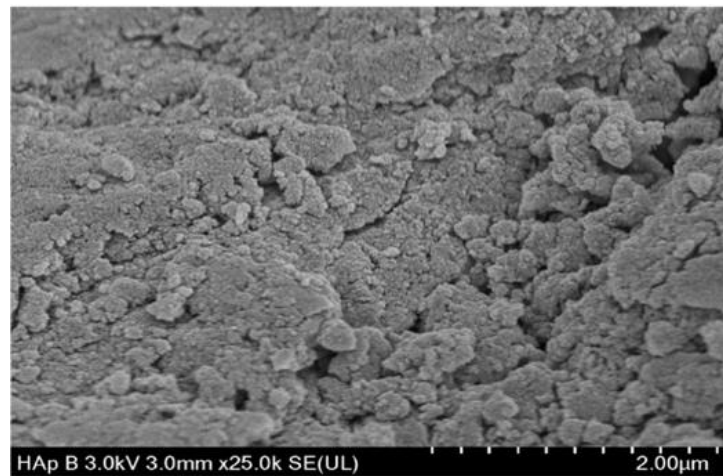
Ultrasound Group.
